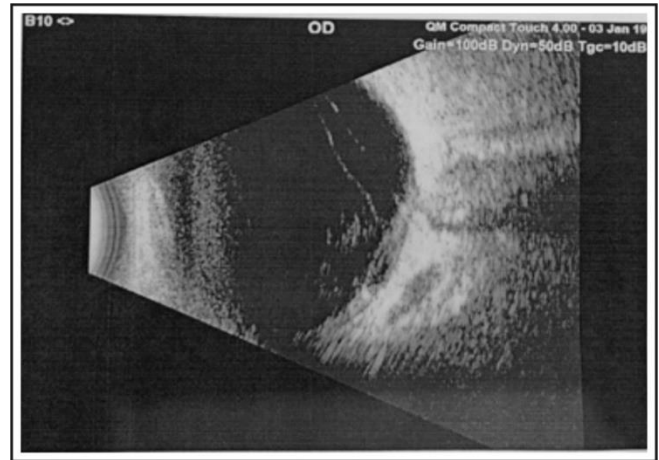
B-Scan Ultrasound of right eye showing tractional band in vitreous.
